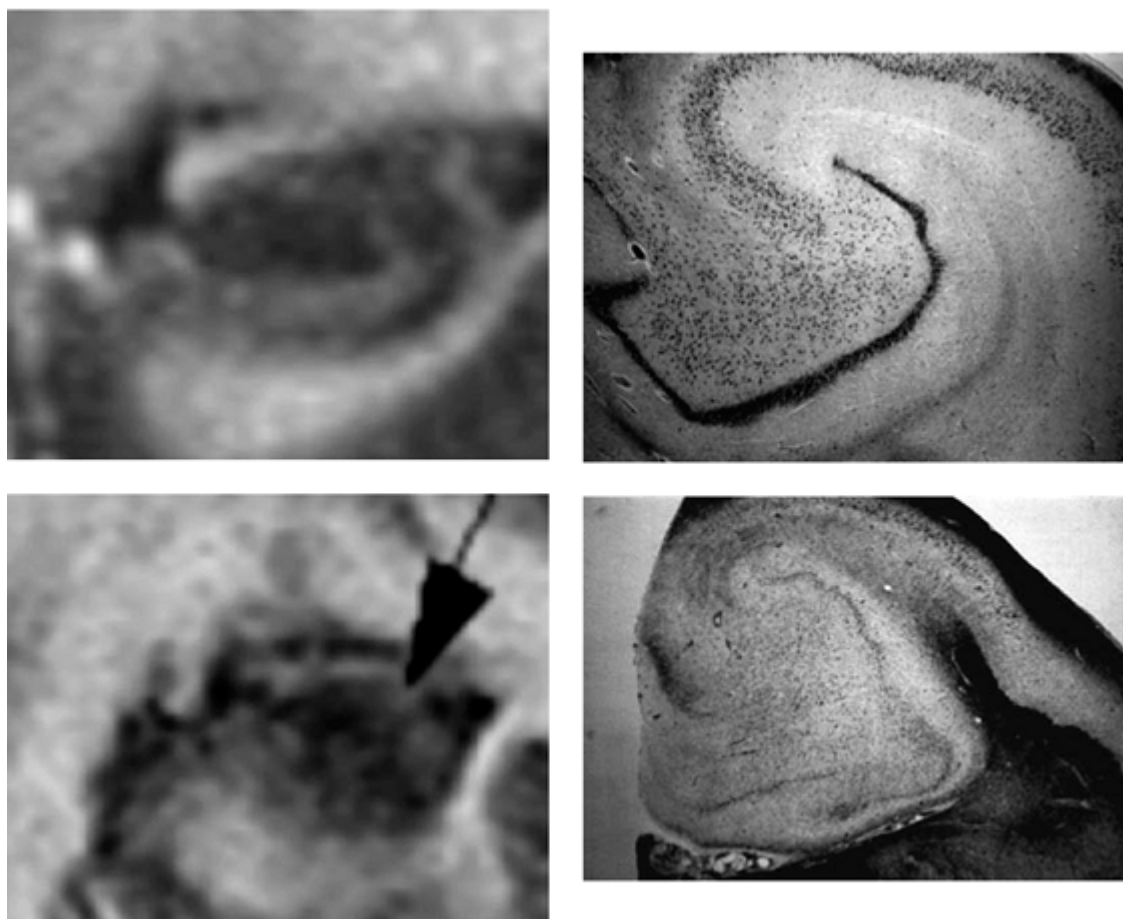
Magnetic resonance and pathology images of a normal hippocampus (top row) and hippocampal sclerosis (bottom row). Different sequences show these features to varying degrees, but a heavily T1-weighted sequence, such as an inversion recovery sequence, seems to reveal contrast in the CA1 and dentate gyrus that parallels the distribution of the pyramidal cells. The basis of this magnetic resonance image contrast is not known. (From Kuzniecky RI, Jackson GD. *Magnetic Resonance in Epilepsy: Neuroimaging Techniques*, 2nd ed. London: Elsevier; 2005; with permission.)
